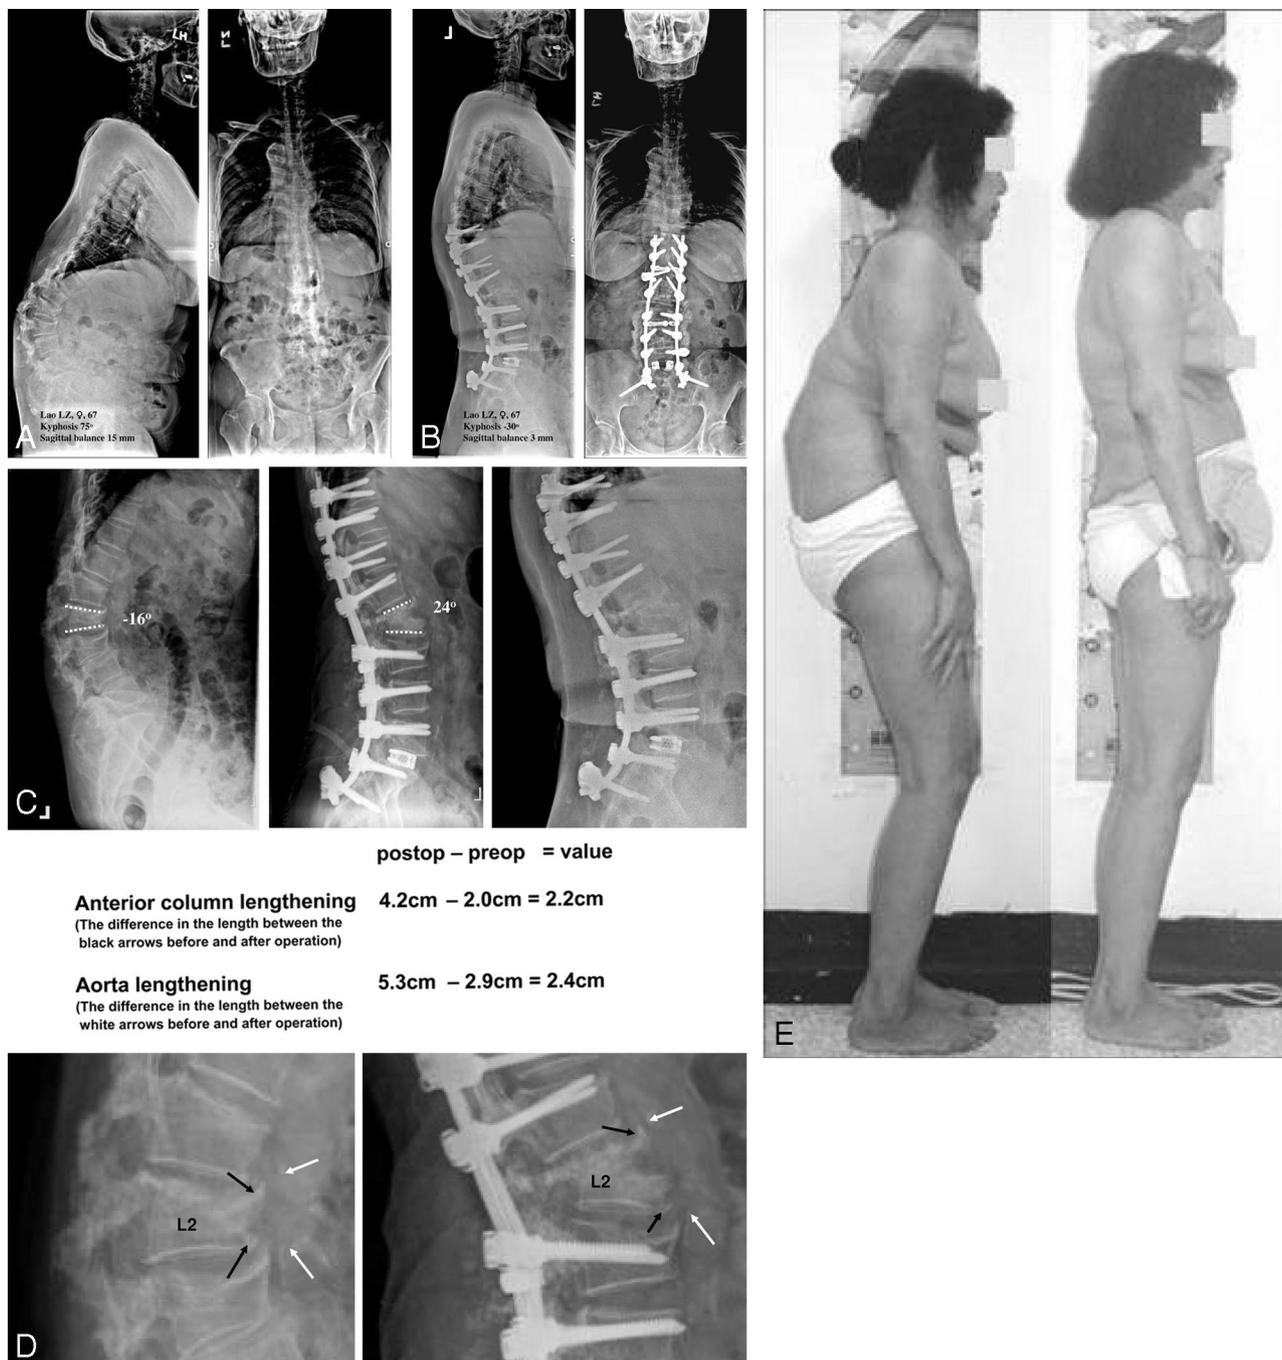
A representative example. A 67-year-old woman with iatrogenic kyphosis (kyphosis after laminectomy). A, Presurgical image showing 75° kyphosis, 15 cm sagittal balance, and 61° T12–S1 lordosis. B, Final values were –30° kyphosis, 3 cm sagittal balance, and –55° T12–S1 lordosis. The patient was pain free and extremely satisfied with the outcome. C, The correction through the osteotomy site was 40°. Sagittal translation joined the mechanism of correction. The anterior open wedge obtained solid fusion. D, The magnitude of aorta lengthening at the level of osteotomy was 2.4 cm, as determined by measuring the difference in the length between the same athermatous calcification marks exactly in front of the osteotomized vertebra seen roentgenographically in the aorta before and after operation. The aorta tolerated the lengthening very well. E, Preoperative and ultimate appearances. Please note, the thoracic spine was lordotic before operation and T10 was not the apex of thoracic curve before surgery. The lordotic thoracic curve was corrected to a normal kyphotic curve by posterior pull of the instrumented low thoracic spine and thus T10 became the apex of the thoracic kyphosis after surgery. Indeed, this is known to predispose to junctional problems. However, from a clinical perspective, the postoperative sagittal balance seems to be the most critical factor in the patient’s clinical outcome. Up to now, no junctional problems occur in this case.
